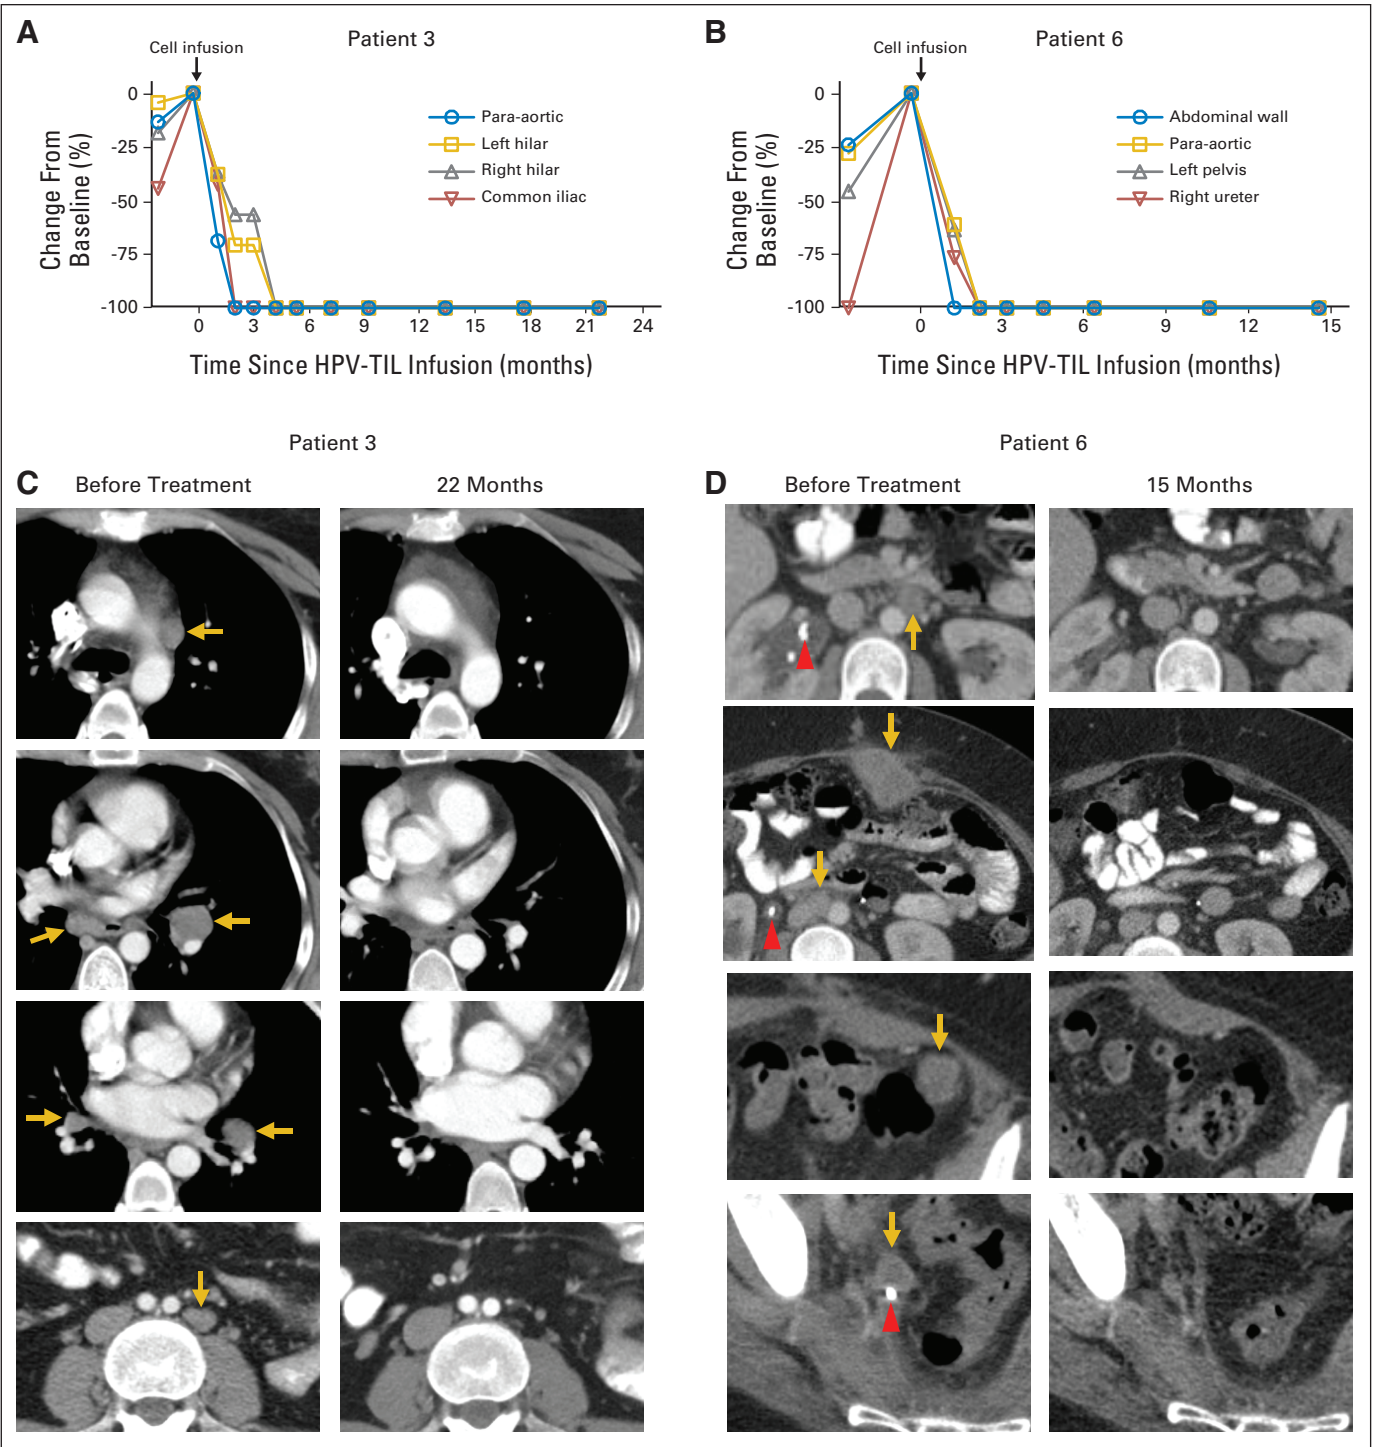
Complete tumor responses in two patients with metastatic cervical cancer treated with tumor-infiltrating T cells selected for human papillomavirus E6 and E7 reactivity (HPV-TILs). Change from pretreatment baseline in longest diameter of individual metastatic tumors after treatment with HPV-TILs for patients (A) 3 and (B) 6. Contrast-enhanced computed tomography scans obtained before treatment and at most recent follow-up for these patients. (C) Patient 3 had disease involving para-aortic, bilateral hilar, subcarinal, and left iliac lymph nodes (gold arrows). Left hilar tumor seen on second and third images from top is same tumor at different slice levels. Patient had no evidence of disease 22 months after treatment. (D) Patient 6 had metastatic disease in para-aortic lymph node, abdominal wall, aortocaval lymph node, left pericolic pelvic mass, and right ureteral nodule (gold arrows). Additional tumors were present on liver surface and were visualized best with magnetic resonance imaging (Data Supplement). Patient had no evidence of disease 15 months after treatment. Red arrowhead indicates ureteral stent that was removed after right ureteral tumor regressed.
